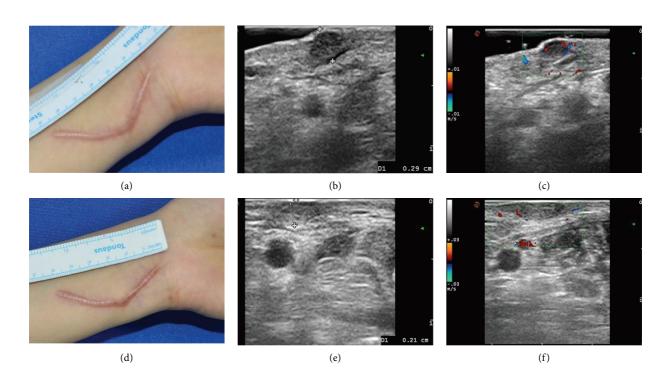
Representative case in Group 1. A 30-year-old female had postoperation hypertrophic scar in the forearm for 6 months. (a, d) Following the 6 sessions of low-dose 5-FU and TAC treatment, clinical improvement was obtained. (b, e) The ultrasound imaging showed the thickness of hypertrophic scar was reduced. (c, f) The ultrasound imaging showed the vascularity reduction following the injection treatment.
